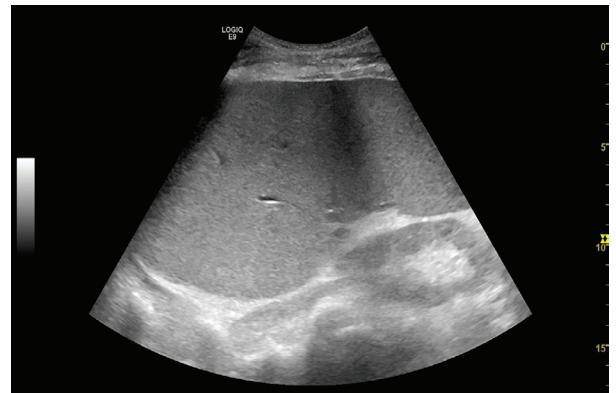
sonography of the abdomen: pronounced splenomegaly in acute myeloid leukemia (here APL)
